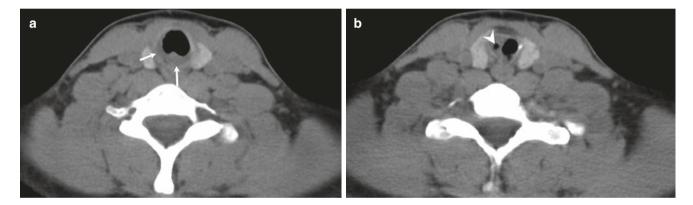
A 21-year-old woman with widespread "granulomatosis with polyangiitis." (a, b) Axial CT images show focal semi-circumferential mucosal thickening (arrows) and ulceration (arrowhead) of the subglottic trachea
